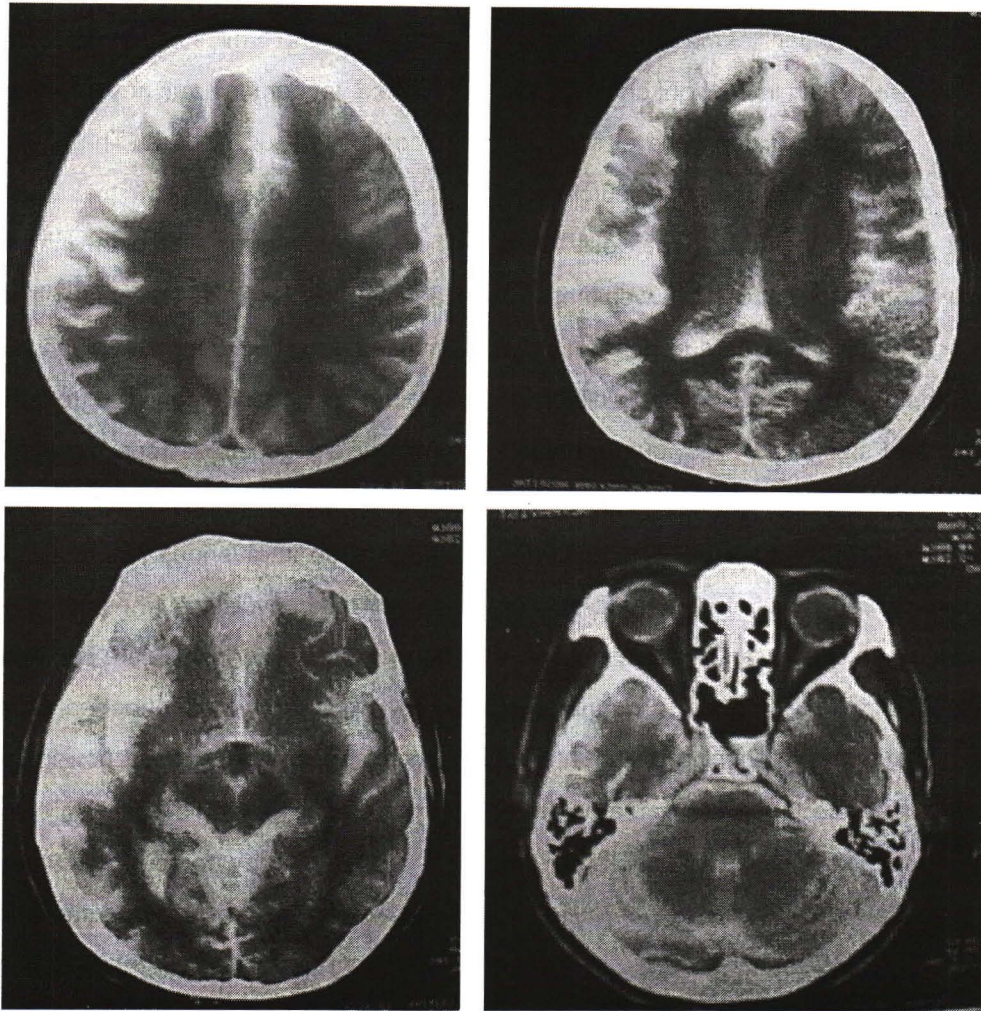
Computerized x-ray tomography report revealed evidence of contrast material remaining in subarachnoid space and ventricles.
